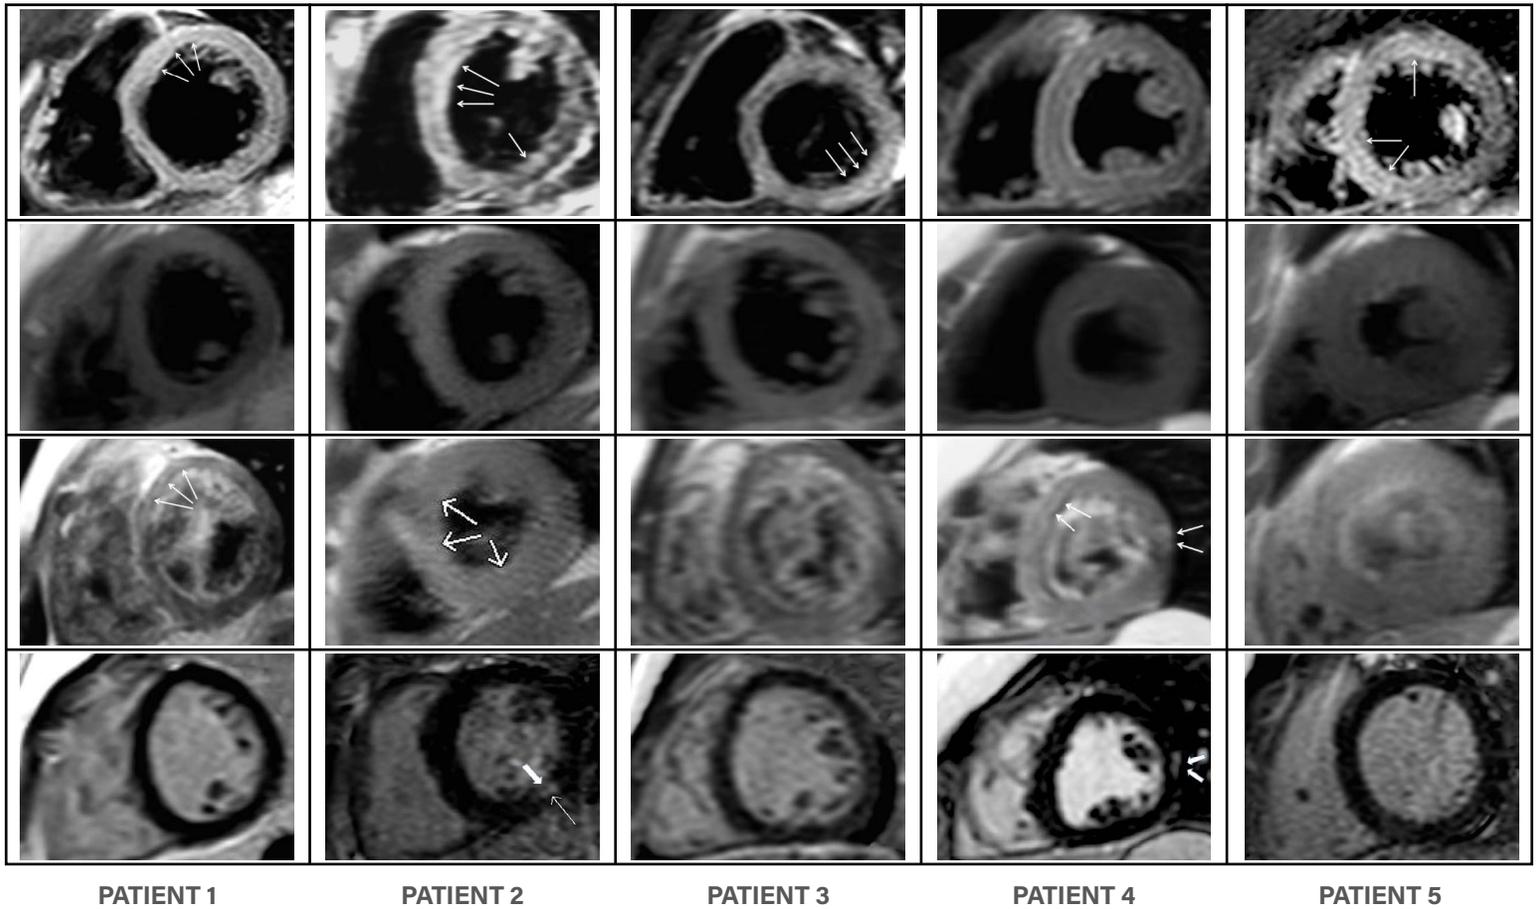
CMR images in five children with clinical diagnosis of myocarditis associated with Multisystem Inflammatory Syndrome in Children (MIS-C) related to COVID-19. The top panel shows T2- weighted images (T2 STIR) which demonstrate areas of high signal intensity (arrows) with average ratios of myocardium over skeletal muscle > 2 denoting myocardial edema in patients 1, 2, 3 and 5. The second and third panel shows T1-weighted images before and shortly after gadolinium administration, respectively. In patients 1, 2 and 4, there is evidence of early gadolinium enhancement (arrows) with calculated myocardial early gadolinium enhancement ratio between myocardium and skeletal muscle >4 in patients 1, 2 and absolute myocardial enhancement >45% in patient 4. The bottom panel demonstrates late gadolinium enhancement in patients 2 and 4 as a small focal lesion in the inferolateral segment of the sub-epicardial region of the left ventricle (arrows).
